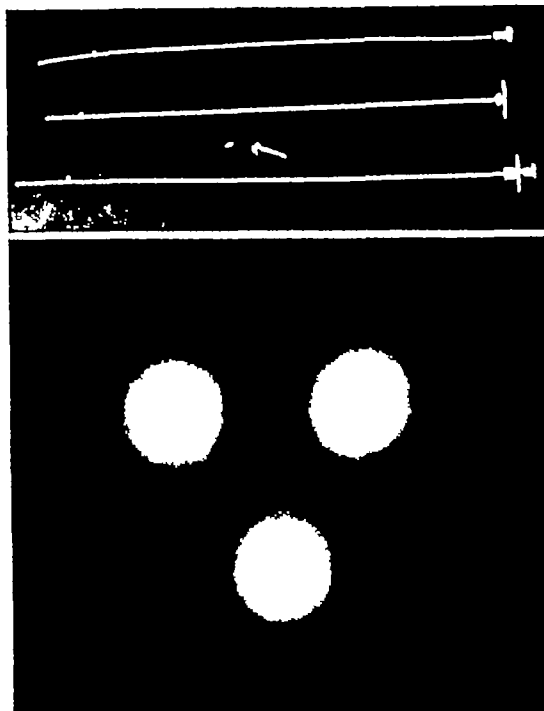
a, above, Radon introducers and radon seed. The upper wire is a stylet removed from its needle directly under it. The bottom instrument is the complete introducer, the stylet being in position within the needle. The arrow points to a radon seed. This is made of gold and has walls 0.3 millimeter in thickness. Its length is 4 millimeters. b, below, Print from x-ray film exposed to 3 radon seeds 4 centimeters apart. The sphere of maximum effect of each seed is thus represented. Seeds should be implanted interstitially to allot each seed approximately this bulk of angiomatous tissue.
